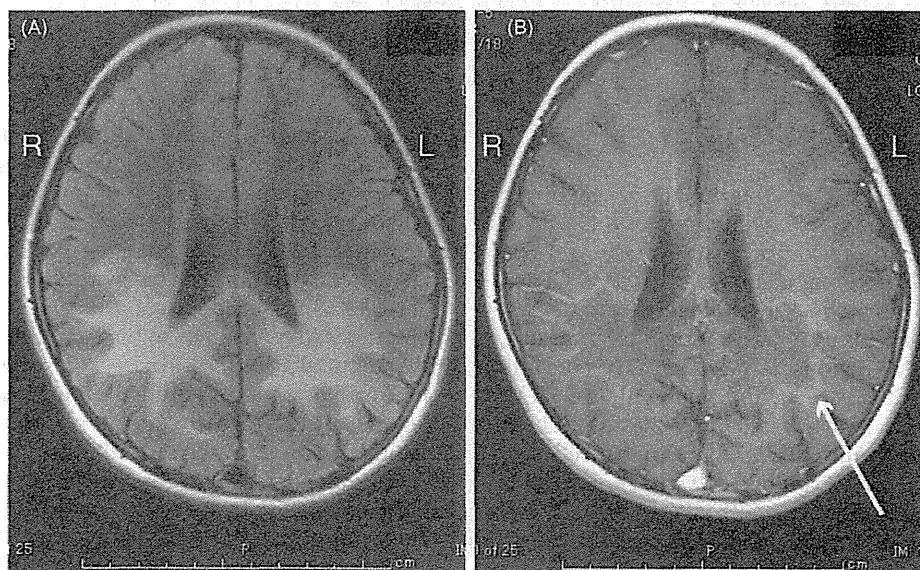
Fluid-attenuated inversion recovery (FLAIR) and post-gadolinium T1-weighted MRI images at the same scan position. The FLAIR image (A) shows hyperintensity (demyelination) of the white matter around each posterior horn of lateral ventricle. Prominent rim enhancement (arrow) is observed after intravenous administration of gadolinium (B), suggesting active areas of demyelination.
